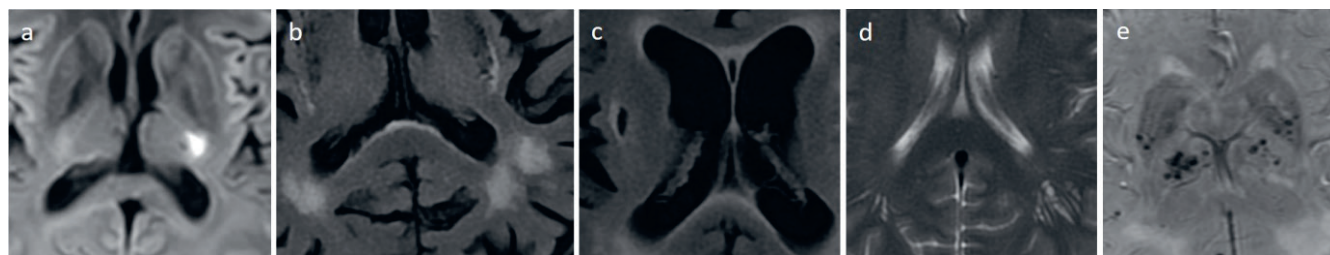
A. Acute lacunar infarction on DWI; B. White matter hyperintensities (WMHs) on the FLAIR image; C. Old lacunar infarction seen on the FLAIR image as a dark fluid-filled cavity surrounded by a hyperintense rim; D. Enlarged perivascular spaces on a T2-weighted image; E. Multiple microbleeds bilaterally within basal ganglia and thalami
